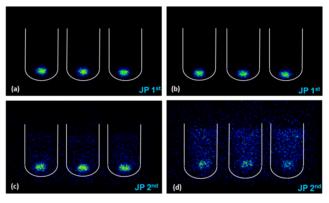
Gamma scintigraphic images of ^{99m}Tc release from HS capsule B after (a) 0 min; (b) 120 min; (c) 246 min and (d) 370 min. Outlines of dissolution vessels have been drawn for presentation only and are not to scale.
